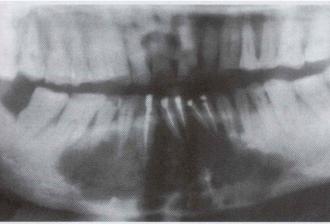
• Glandular odontogenic cyst. A. Expansile lesion of the anterior mandible. B, The panoramic radiograph shows a large multilocular radiolucency. (Courtesy of Dr. Cheng-Chung Lin.)
